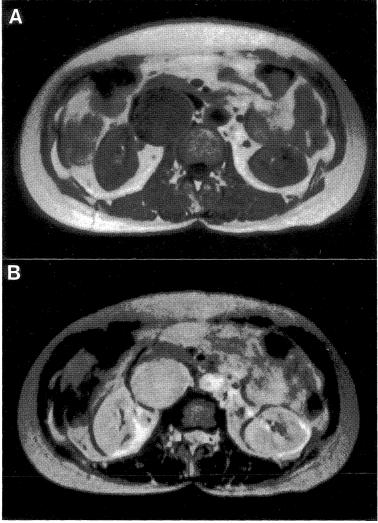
MRI scan displayed the low intensity mass on T1 weighted image (A) and high intensity mass on T2 weighted image (B).
